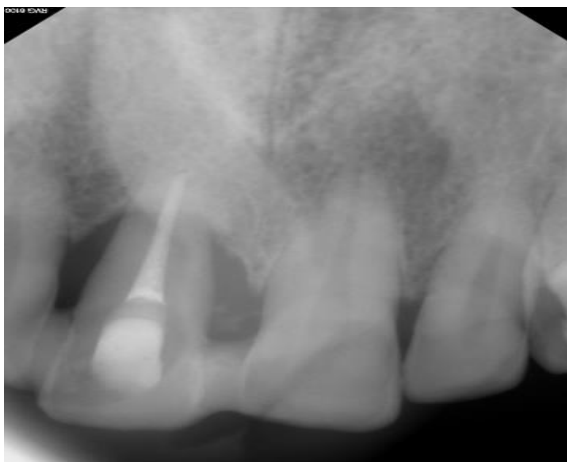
36th month radiograph
